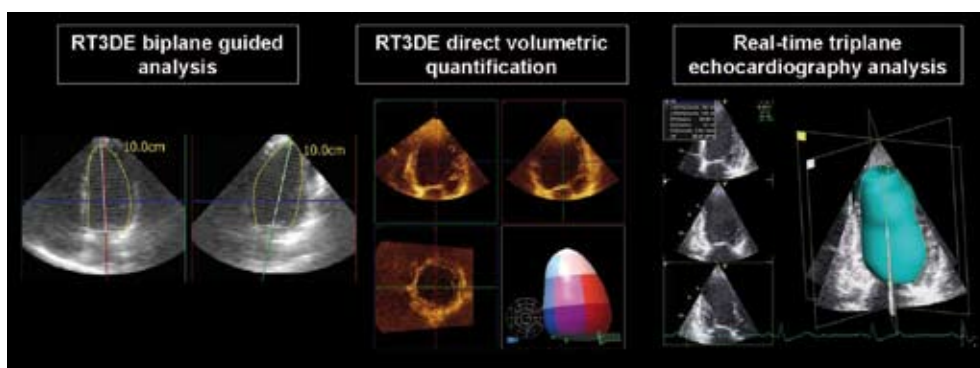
LV volumes and ejection fraction assessment with 3D echocardiography. Several methods of analyses are currently available: RT3DE biplane guided analysis (left), direct volumetric quantification (middle), and real-time triplane echocardiographic analysis (right).
